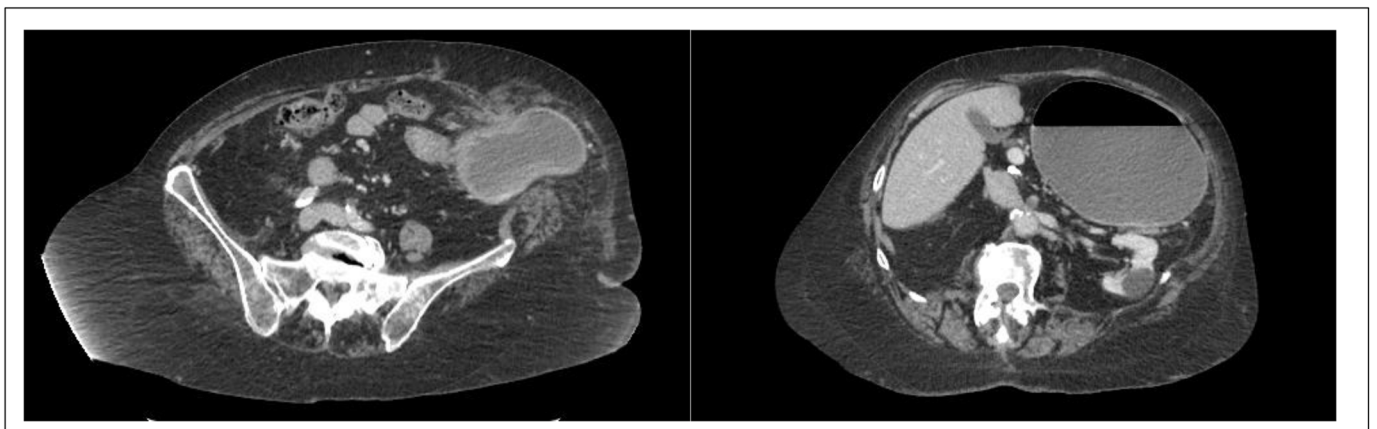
(Left) Axial Computed Tomography view of Parastomal Hernia containing portion of the stomach. (Right) Axial Computed Tomography view of Air/Fluid level in stomach in setting of gastric outlet obstruction secondary to gastric containing Parastomal Hernia.
